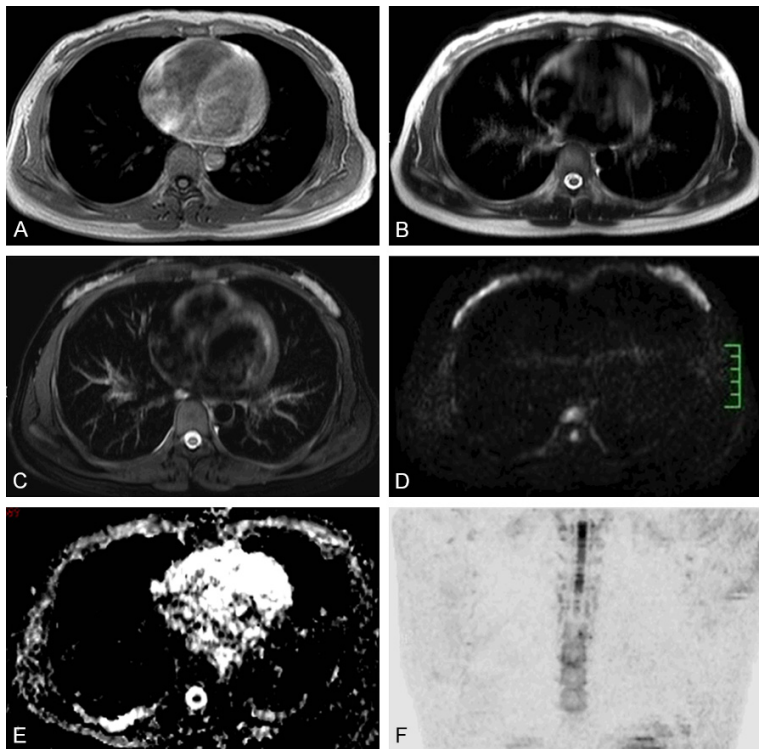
Manifestation for the normal chest MRI, DWBS and ADC images. A. T1WI image. B. T2WI image. C. T2WI-SPAIR image. D. DWBS image. E. ADC image. F. MPR image.
